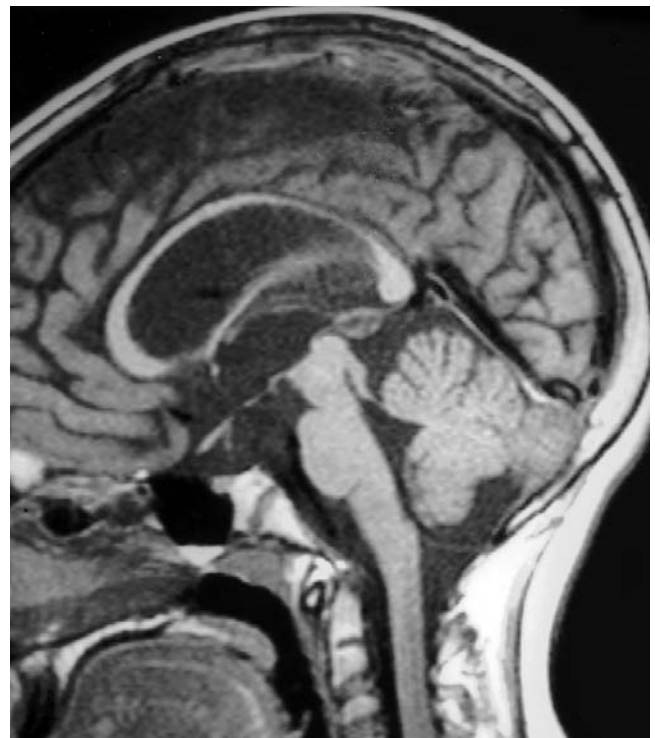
Preoperative sagittal MRI shows the basilar artery and the third ventricle. The third ventricle should measure at least 3 to 4 mm to accommodate the endoscope.
